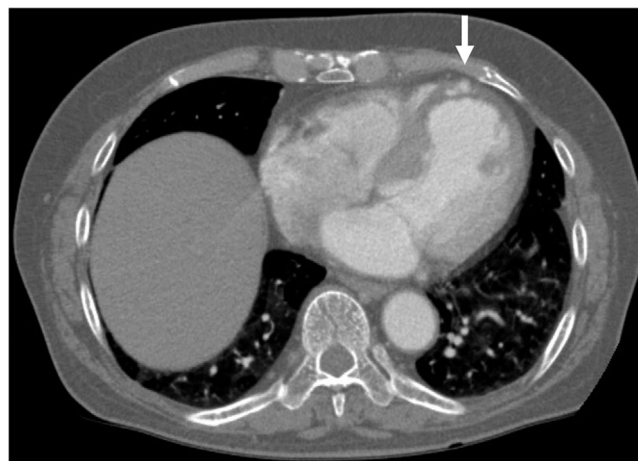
Contrast-enhanced computed tomographic scanning showed an intramyocardial extravasation (arrow)
